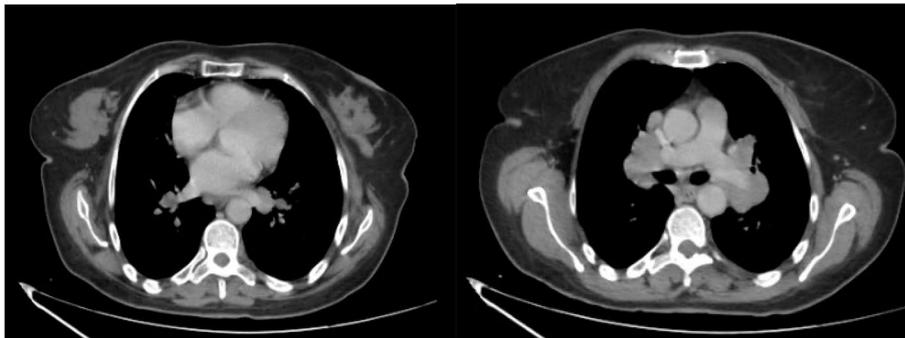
Chest CT scan: mediastinal window revealing confluent bilateral mediastinal lymphadenopathies without necrosis, calcification, or compression of the tracheobronchial tree
